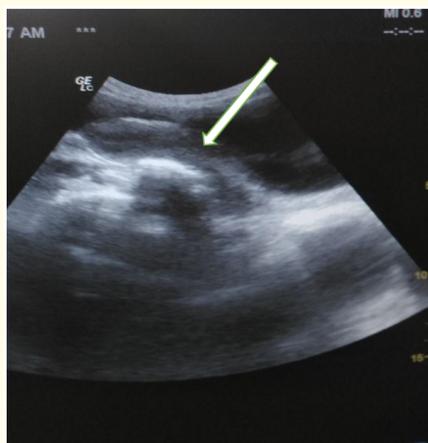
Transabdominal ultrasound of another empty uterus with uterine slit. The arrow is uterus with endometrial slit.
